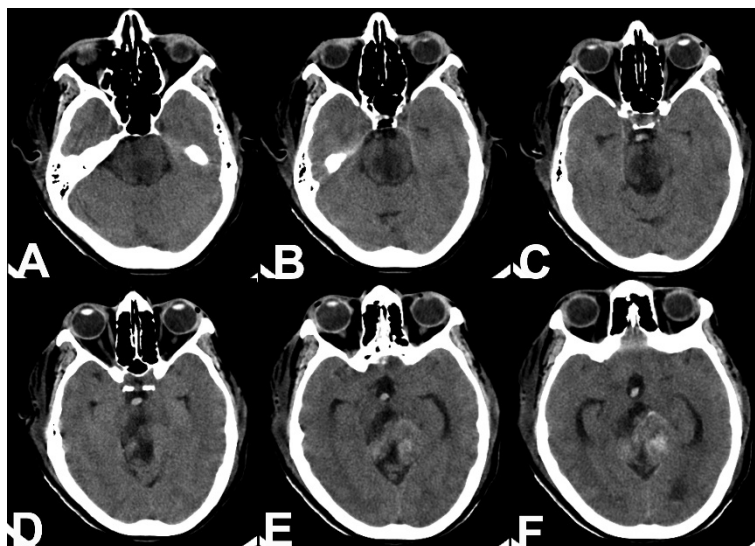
Post-operative follow up CT scan showing diffuse hypodensity involving the midbrain
